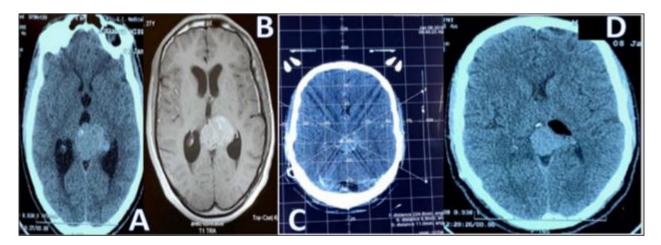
Patient of our study with pineal region process, A: Brain CT shows a process in the pineal region with the onset of hydrocephalus. B: Brain MRI shows the same tumor process enhanced after gadolinium injection.C: frame-in-place locator scann, biopsy target chosen in a contrast-enhanced area. D: Follow-up CT scan shows pneumocephalus at the biopsy site
